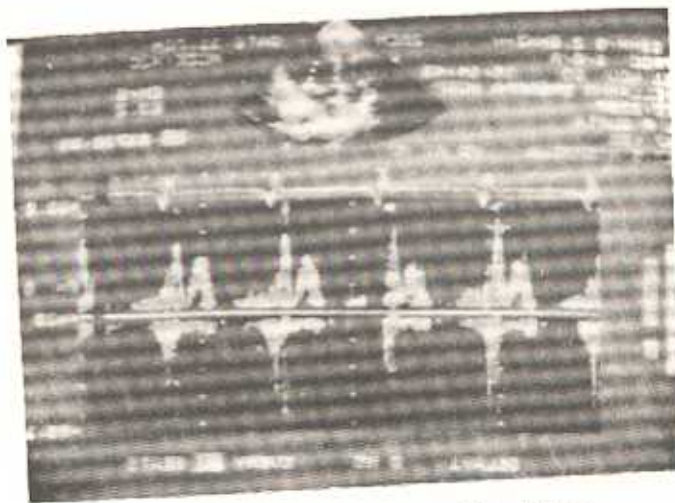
Pulsed Doppler Velocities at Mitral Valve Showing A>E Suggesting LV Diastolic Dysfunction.
